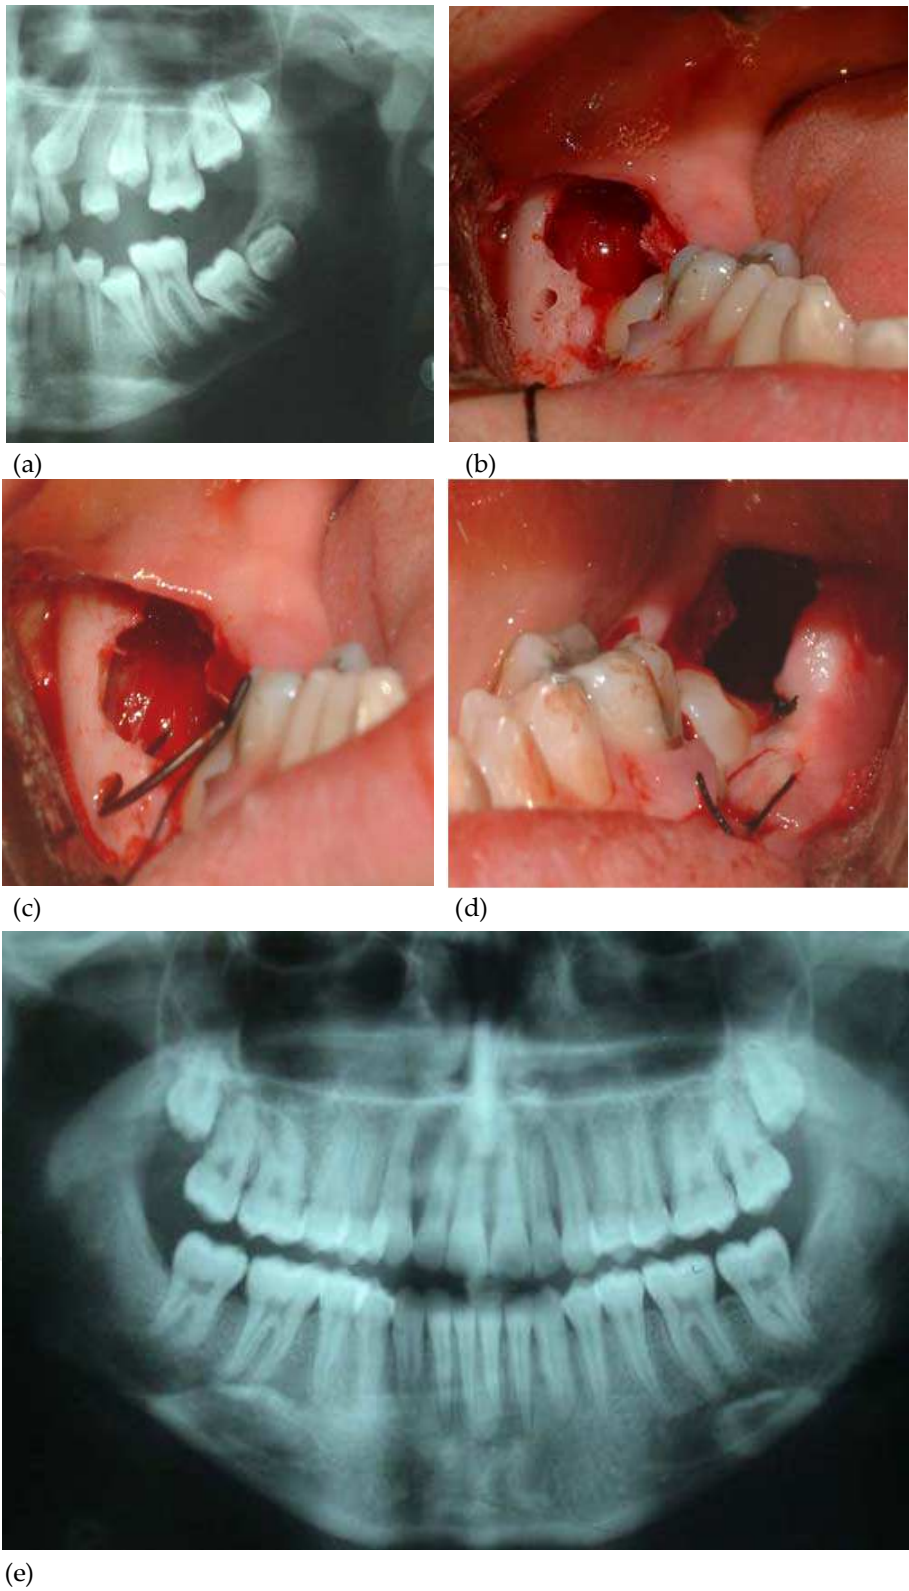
A. Radiograph of a double impaction in the mandible in a 13 year-old boy. B. The 32rd molar has been removed. A hole is drilled in the buccal cortex. C. 3-0 silk suture is passed through the superior part of the flap and then through the buccal cortex. D. the flap is tied down. E. Radiograph 2.5 years post-treatment.
